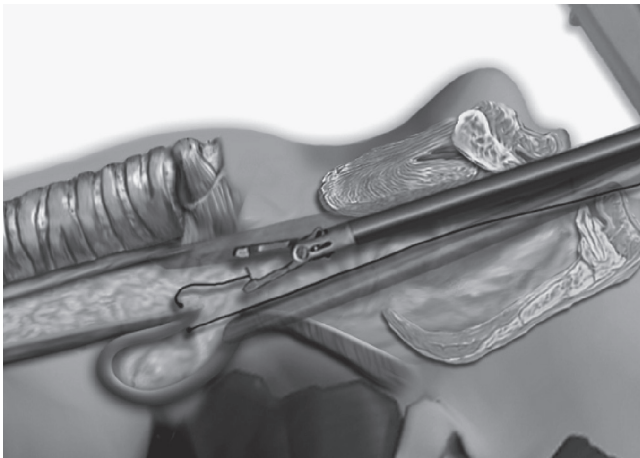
■ Traction stitch placed in the septum with use of 2-0 Ethibond on an Endo Stitch device (U.S. Surgical Corp., Norwalk, CT). This prevents the septum from being “squeezed” out of the stapler jaws. (From Morse CR, Fernando HC, Ferson PF, et al: Preliminary experience by a thoracic service with endoscopic transoral stapling of cervical [Zenker’s] diverticulum. *J Gastrointest Surg* 11:1091–1094, 2007. Used with permission, Springer Verlag.)
